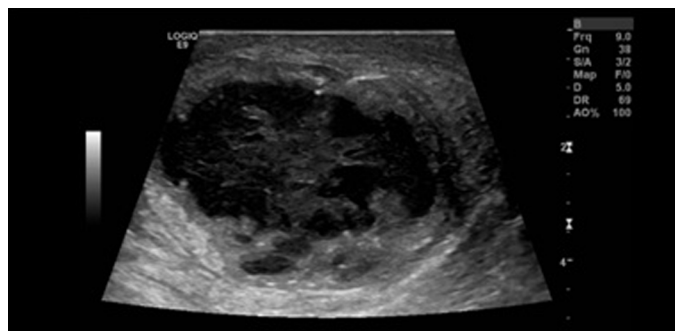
Scrotal ultrasound.
